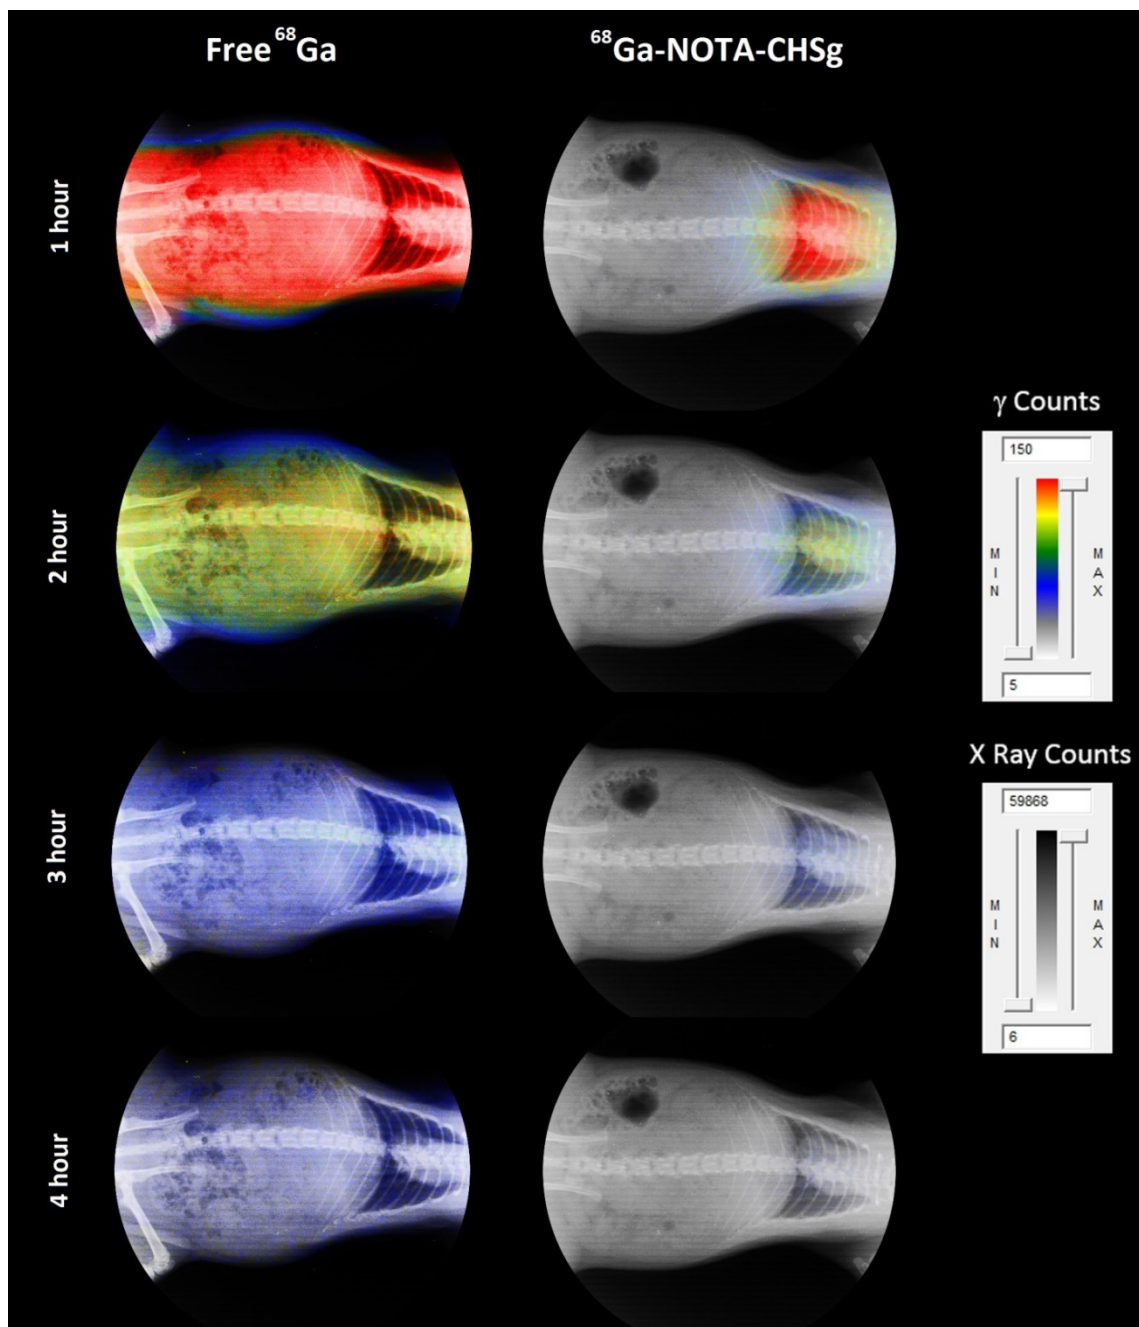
Non decay-corrected, un-collimated full body X-Ray/Autoradiography for free ^{68}Ga and $^{68}\text{Ga-NOTA-CHSg}$ at 1, 2, 3 and 4 hours.
